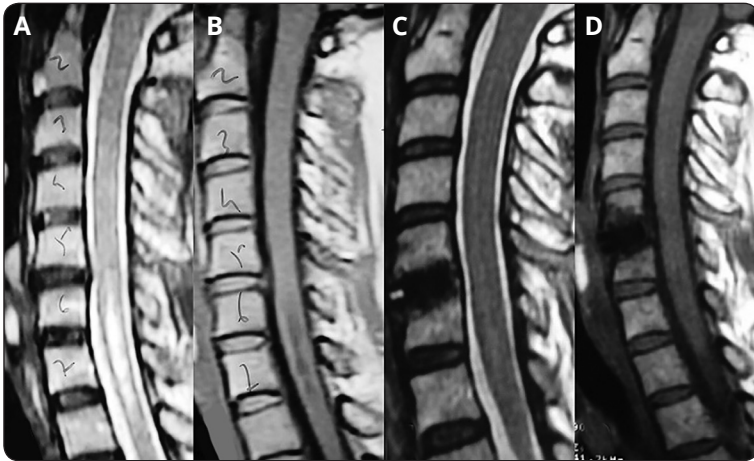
Case 8 preoperative T2 weighted A and T1 weighted B MRI of distal type Grade 2 syrinx associated with C5-C6 disc herniation. Postoperative T2 weighted C and T1 weighted D MRI shows resolution of syrinx
